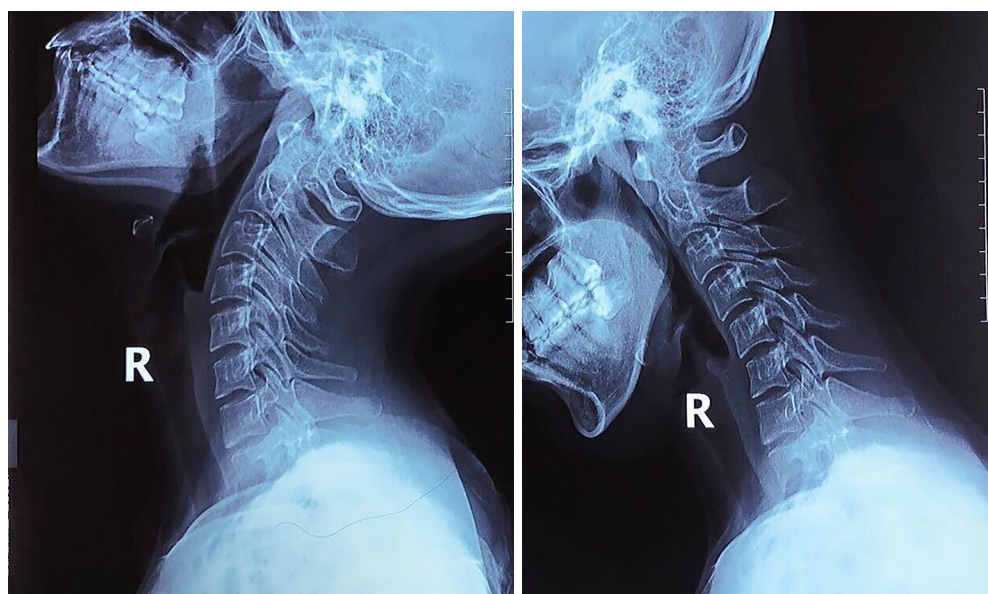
The hyperflexion-extension plain film examination of case 2.
